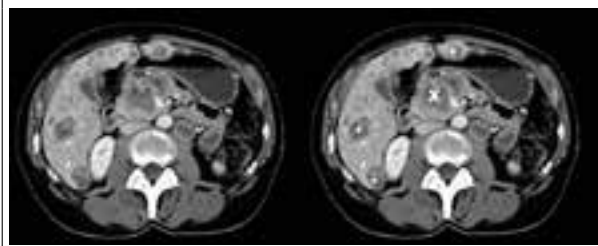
Abdominal CT scan showing the pancreatic tumour invading surrounding tissues (marked by X in figure 2a)
